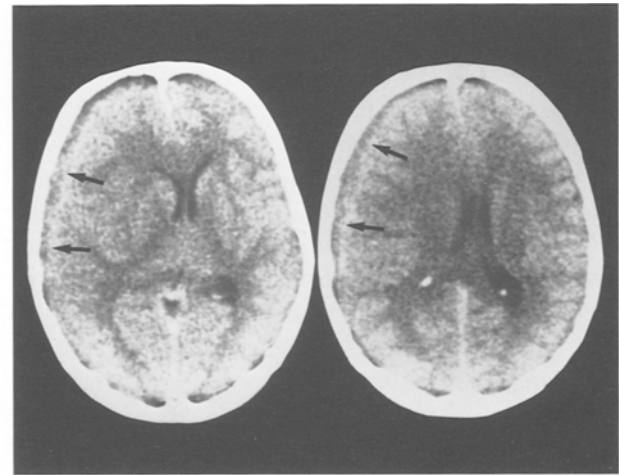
Computed tomography eleven days after the onset in case 2, demonstrating an increase in the volume of the haematoma associated with decreased attenuation (arrows)
